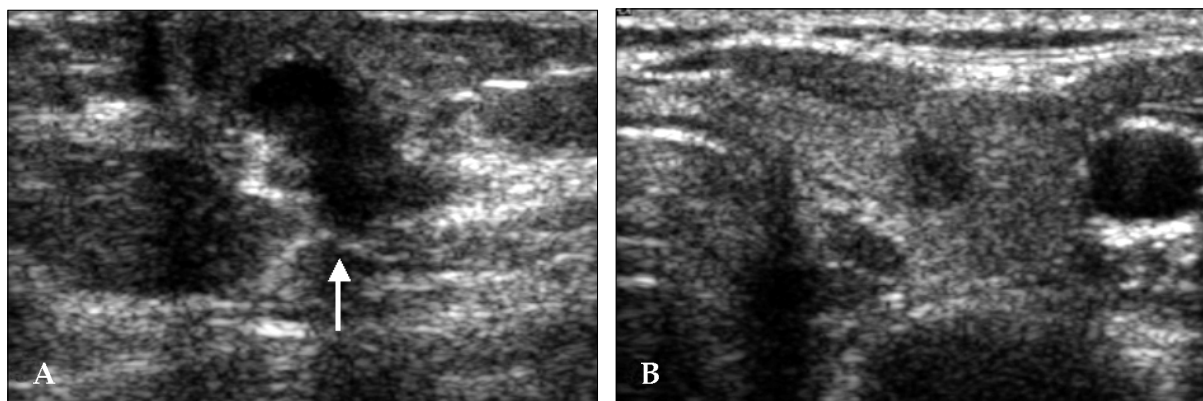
51-year-old woman with breast cancer; thyroid cancer was detected 12 months after mastectomy. (A) Preoperative breast sonography showed an irregular hypoechoic mass (arrow) at left subareolar area, proving infiltrating ductal carcinoma. Initial thyroid sonography was negative. (B) 12-month follow-up sonography showed an approximately 5 mm-sized taller-than-wider hypoechoic nodule at the right thyroid gland, proving papillary carcinoma.
